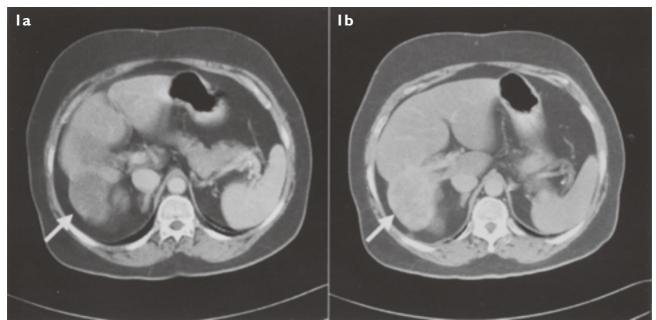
Enhanced axial CT image (portal venous phase) shows peripheral nodular enhancement and a hypodense centre (arrow), Fig. 1b Enhanced axial CT image (delayed phase) shows peripheral filling-in (arrow).
